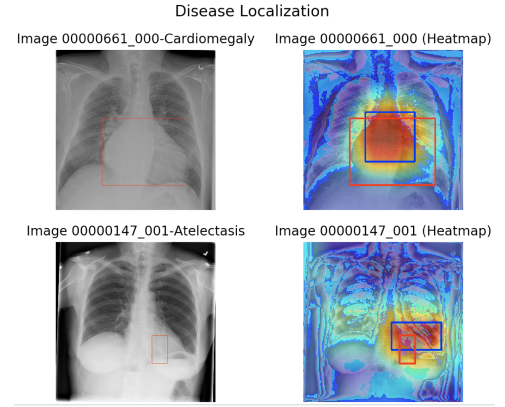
Identification of Differences in X-Rays Using Heat-Maps
